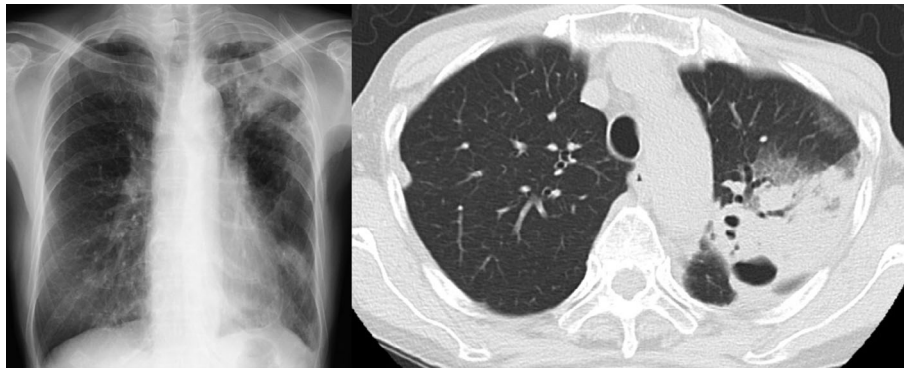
(A) Chest radiography and (B) computed tomography on admission showing cavities and consolidations in the left upper lobe
